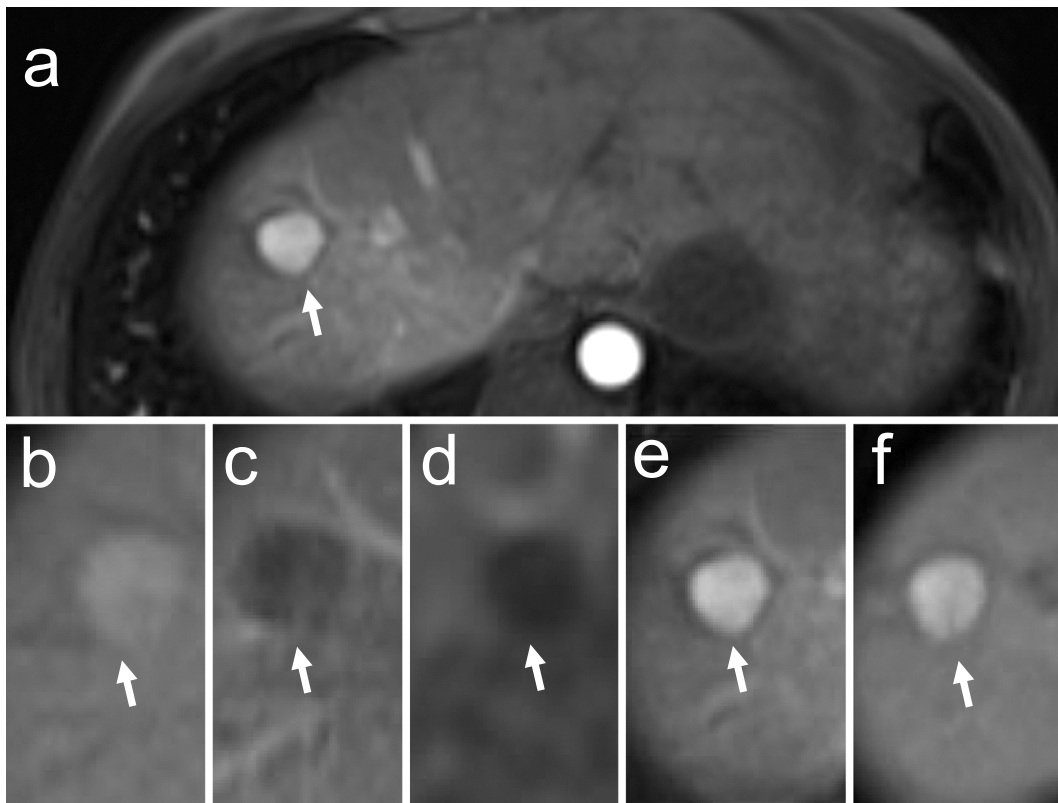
Gd-EOB-DTPA MRI showed an 18 mm S2 mass with a moderately high intensity in T1-WI (b), moderately low intensity in T2-WI (c), moderately low intensity in diffusion (d), homogeneous arterial enhancement (a, e), and high intensity in the hepatobiliary phase (f).
